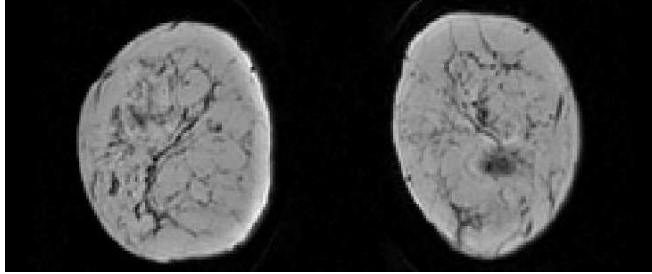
(a) shows a clinical MR image corrupted by intensity inhomogeneity. Fig. 1(b) shows the estimated bias field using our algorithm and Fig.1(c) shows the corrected image using the bias field in (b). The membership map for dense tissue class is shown in Fig.1(d). Applying standard FCM algorithm
